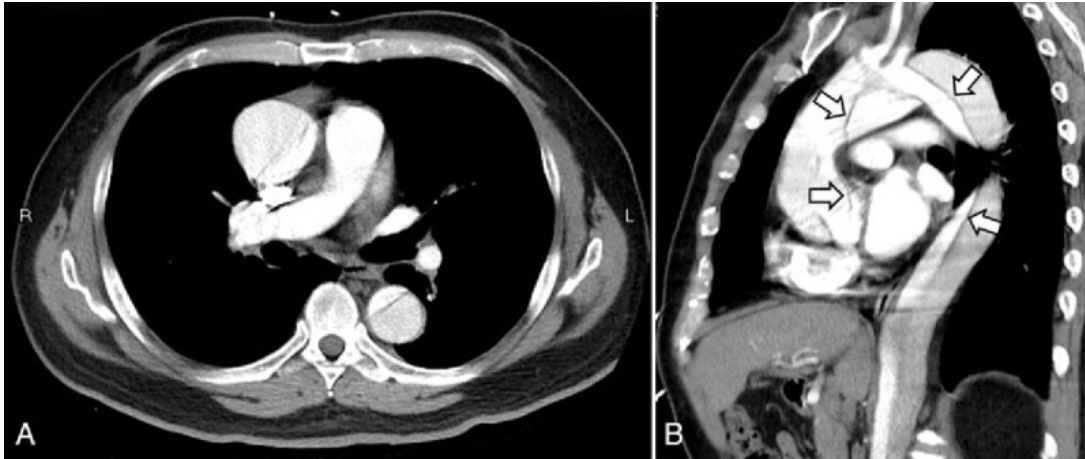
Contrast-enhanced computed tomography of chest indicated type A aortic dissection from aortic root.
